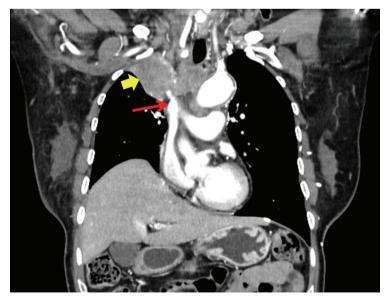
Coronal view of the chest CT image showed a right upper lobe lung tumor (yellow arrow) compressing the superior vena cava (red arrow).
